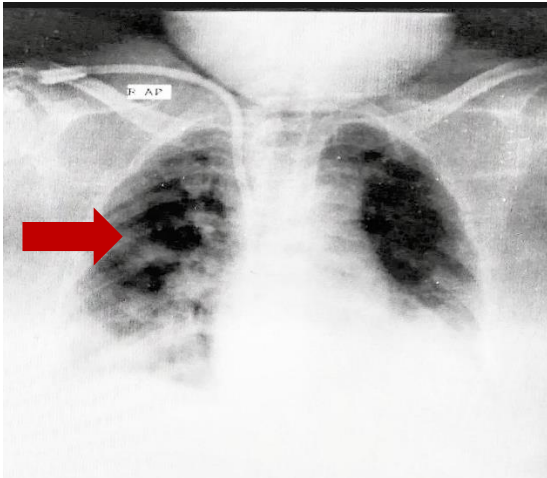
X-ray Chest AP view showing bilateral patchy non-homogenous opacities more prominent in the lower lung zones with bilateral pleural effusion.
